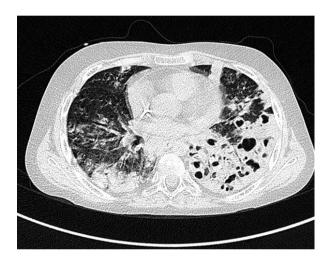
Transaxial HRCT imaging of the chest showing massive confluent patchy opacities in both lungs, with irregular cavities indicating collapse of the lung parenchyma, accompanied by fibrosis and dilation of the peripheral portions of the bronchi and mediastinal lymphadenopathy
